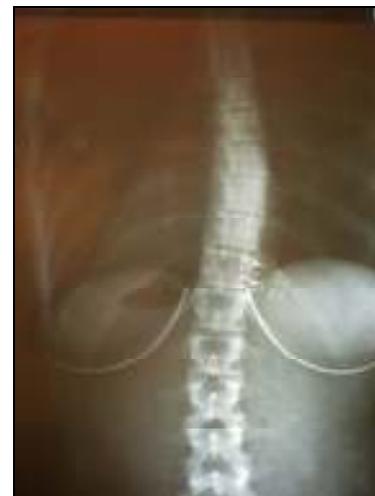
Anteroposterior radiograph 4 years after starting care.
